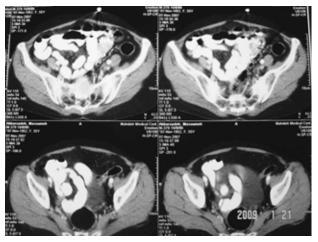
Computed tomography scan reveals a mass measuring 5  $\times$  3.5 cm.
